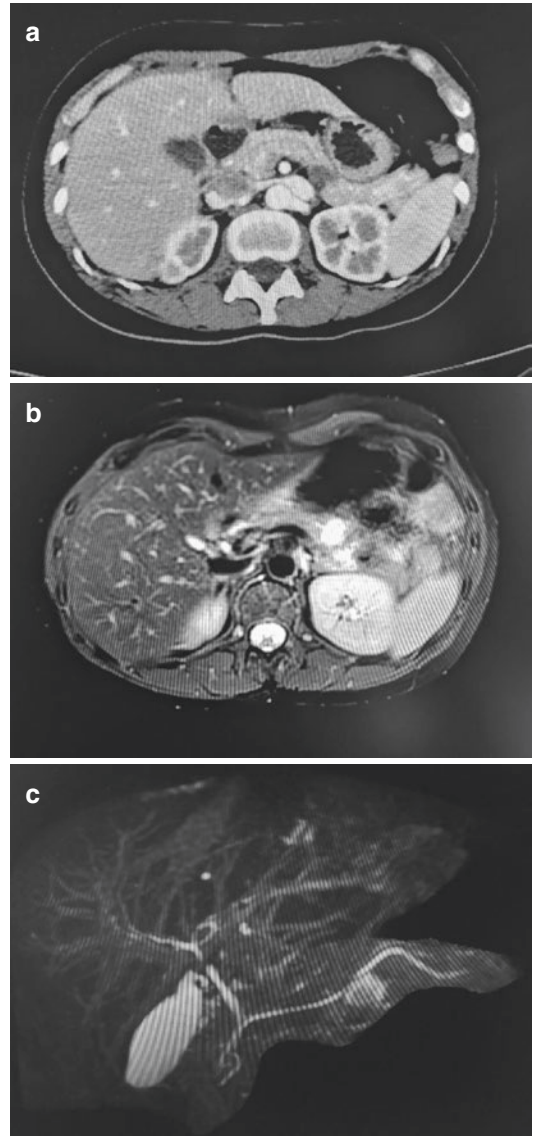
(a–c) CT and MR image showed a tumor located at the body of the pancreas
